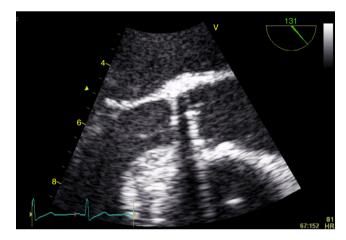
Transesophageal echocardiogram in mid-esophageal long-axis view of the aortic prosthesis. No signs of prosthetic valve endocarditis were visualized at this point.
